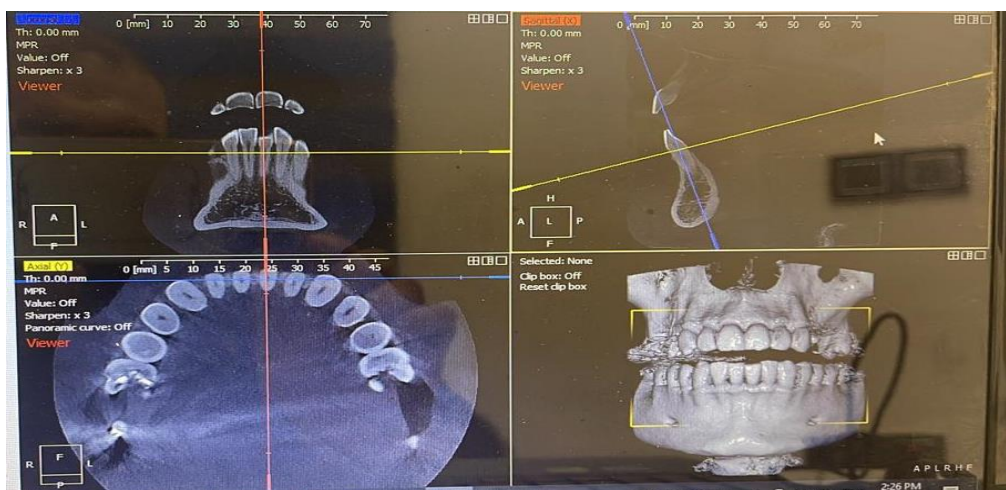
For this research, we utilized CBCT data that participants willingly provided their informed consent for by signing pertinent papers.
